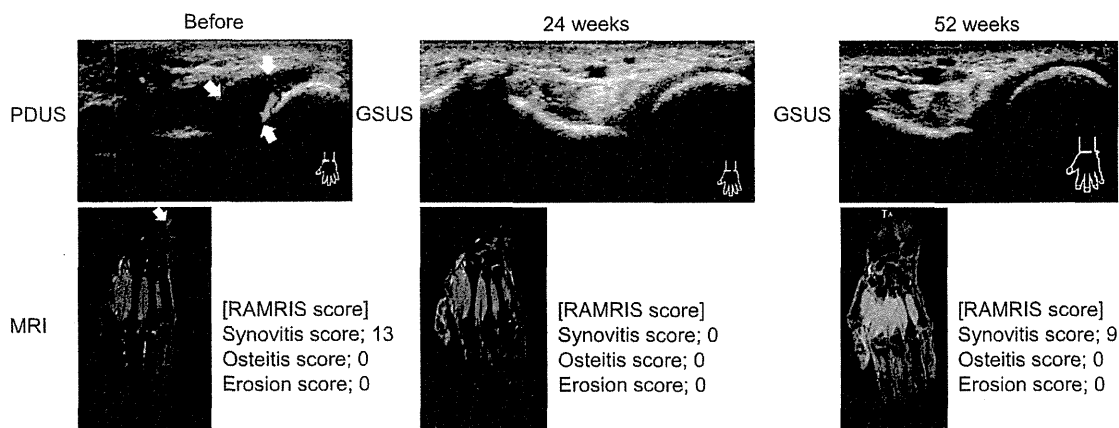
Improvement of clinical measures, US scores and imaging in the 12 months after induction of tocilizumab in Case 2. Thickened synovium expands from the distal radio-ulnar joint to the distal ulna at baseline. US shows power Doppler signals (grade 2) and MRI short time inversion recovery (STIR) shows high intensity in thickened synovium. These abnormal findings disappeared at 52 weeks after introduction of TCZ. The images of US show the distal ulna of left hand (transverse scan and dorsal aspect). The images of MRI show left hand (coronal section). Abbreviations are as in the Figure 1 legend. GSUS, gray scale ultrasonography.
